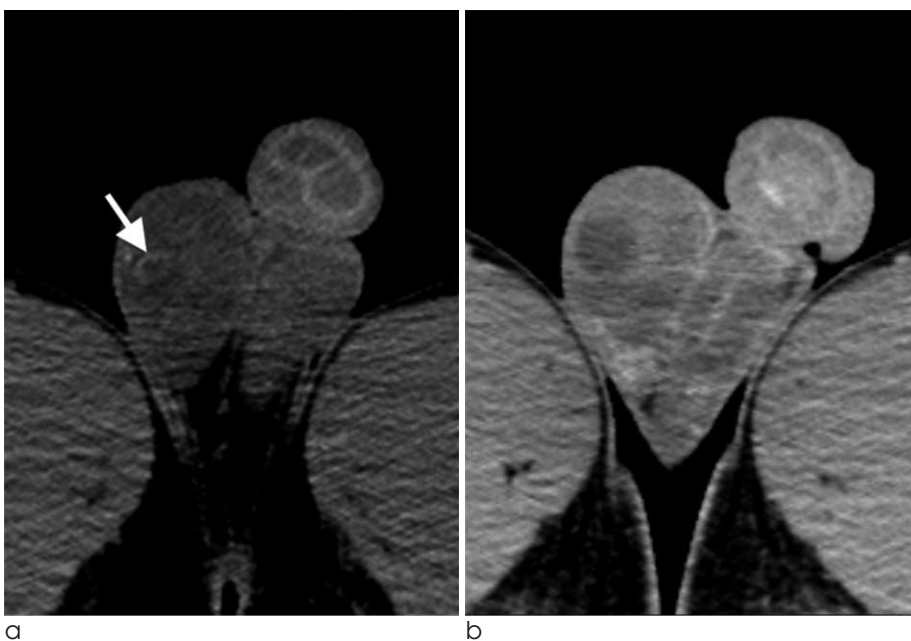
CT shows a well-defined non-enhancing cystic mass in the right testis. (a) Non-enhanced axial CT image reveals focal curvilinear calcification (arrow). (b) Enhanced axial CT image shows no enhancement of the mass.
